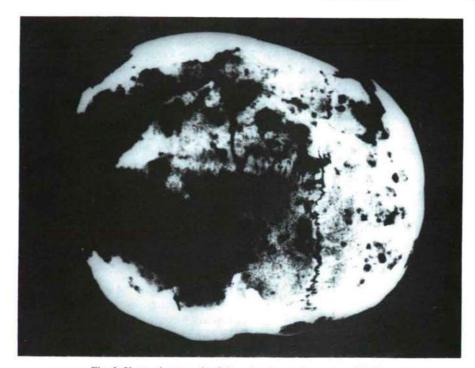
X-ray photograph of the calvarium to be seen on Fig. 2. Finding Nr. 8270, grave Nr. 135, mature male
